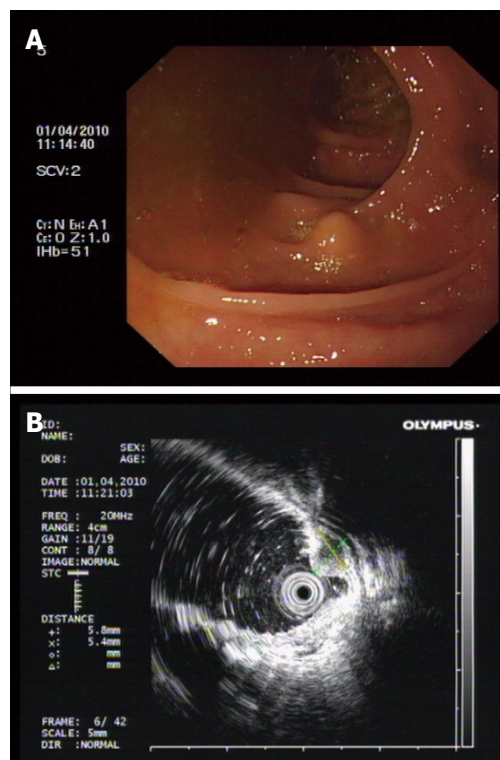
Preoperative examination. A: A 0.8 cm submucosal lesion was observed 60 cm from the anal verge (ascending colon). The mass was sessile, the mucosal surface was smooth, with non-necrotic erosion, and was non-circumferential. B: Ultrasonographic examination revealed a 0.5 cm hypoechoic submucosal lesion without muscularis propria involvement.
